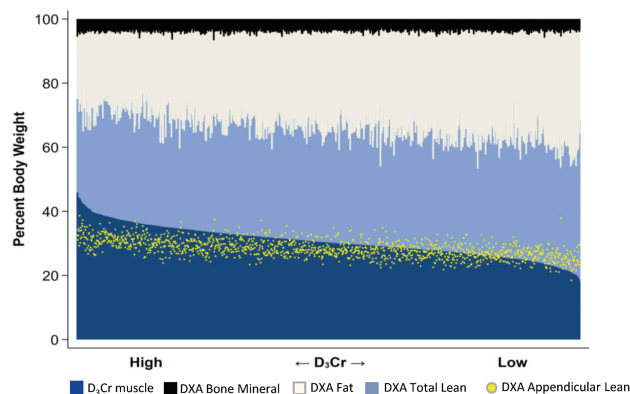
Comparison of components of body composition, each as a percent of body weight, in 1,376 older men. In combination, the three-compartment DXA measures of bone mineral, fat and total lean equal 100%. Superimposed are the measures of D₃Cr muscle and DXA ALM. The men are ranked with those with highest D₃Cr on the left and lowest on the right. ALM = appendicular lean mass; DXA = dual-energy x-ray absorptiometry. Full color version is available within the online issue.
